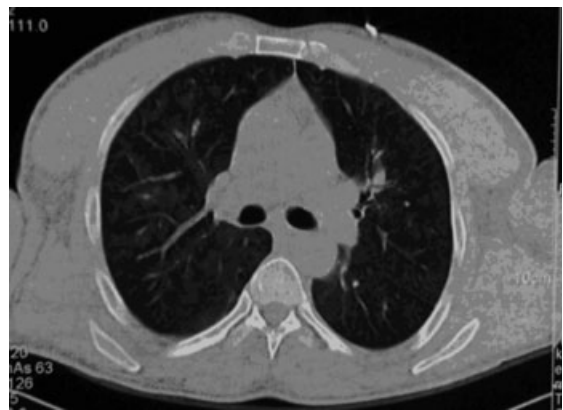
Chest CT-scan image after tracheal extubation.
